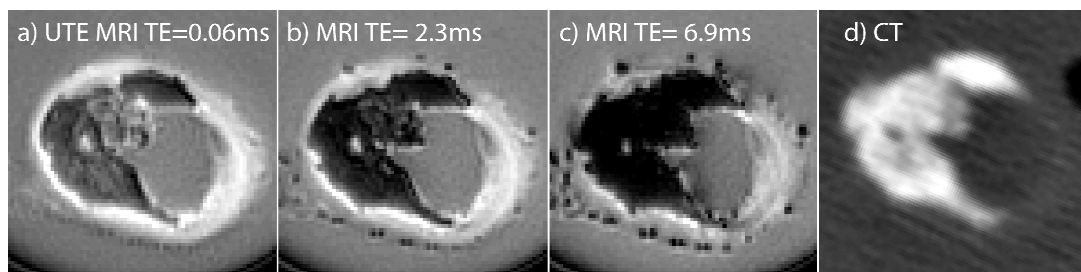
(a) Ex vivo images of human carotid sample acquired with the high-resolution Ultra-short TE (UTE) imaging sequence, and the corresponding in-phase echoes (b,c). The signal from the calcified plaque is clearly identifiable and confirmed by the CT (d). Note the low proton density and lack of signal from the calcification in the longer TE images. The MR images have an isotropic spatial resolution of $200\mu\text{m}$. The CT image has a resolution of $137\times 137\times 700\mu\text{m}$.
